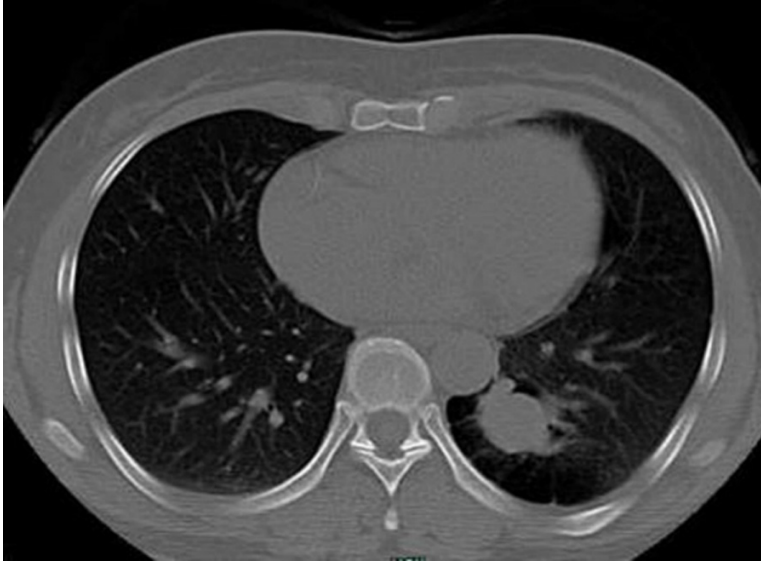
CT scan of the female patient. The CT scan revealed a 3.5 × 3.0-cm mass in the left lower lobe.
